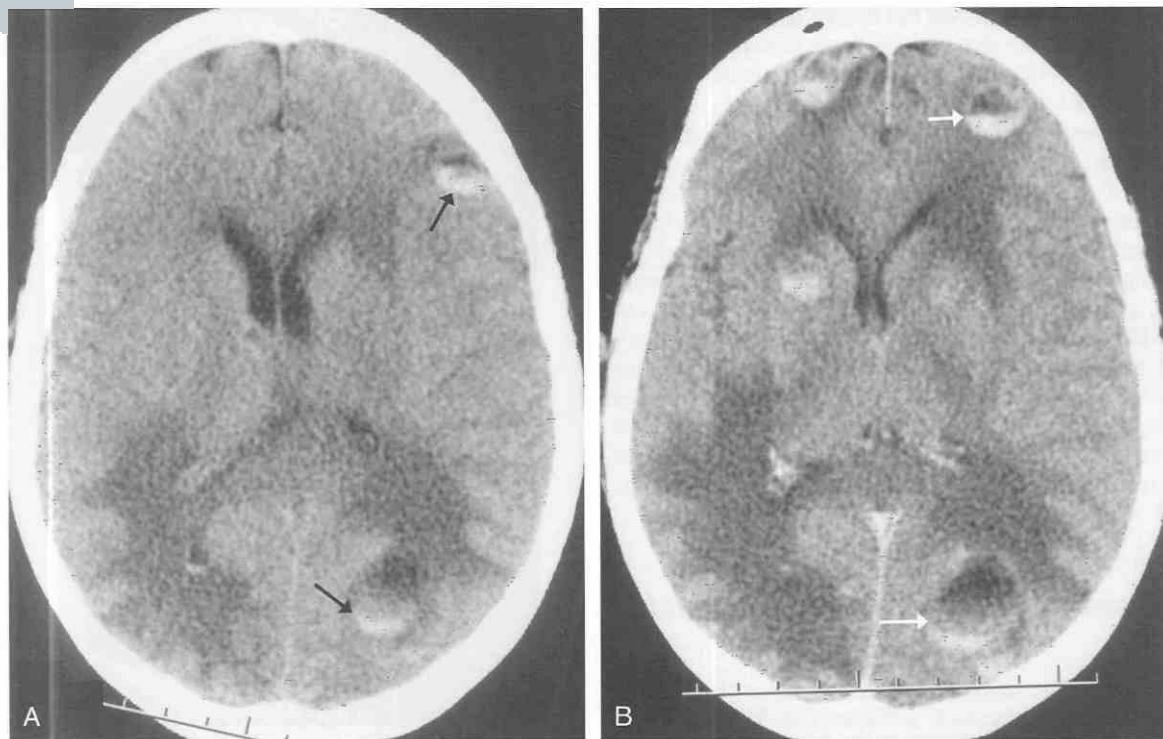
Hematogenous metastases of melanoma to the brain with intratumoral hemorrhage. *A*, An axial noncontrast CT image demonstrates at least four foci of varying size located at gray/white junctions in both cerebral hemispheres. All four lesions contain blood/fluid levels (arrows) indicating the presence of intratumoral hemorrhage. The lesions in the frontoparietal regions bilaterally and the left deep frontal area have provoked considerable surrounding edema. *B*, An axial CT image at an adjacent level following intravenous contrast injection demonstrates faint ringlike contrast enhancement of the margins of several of these tumors (arrows).
